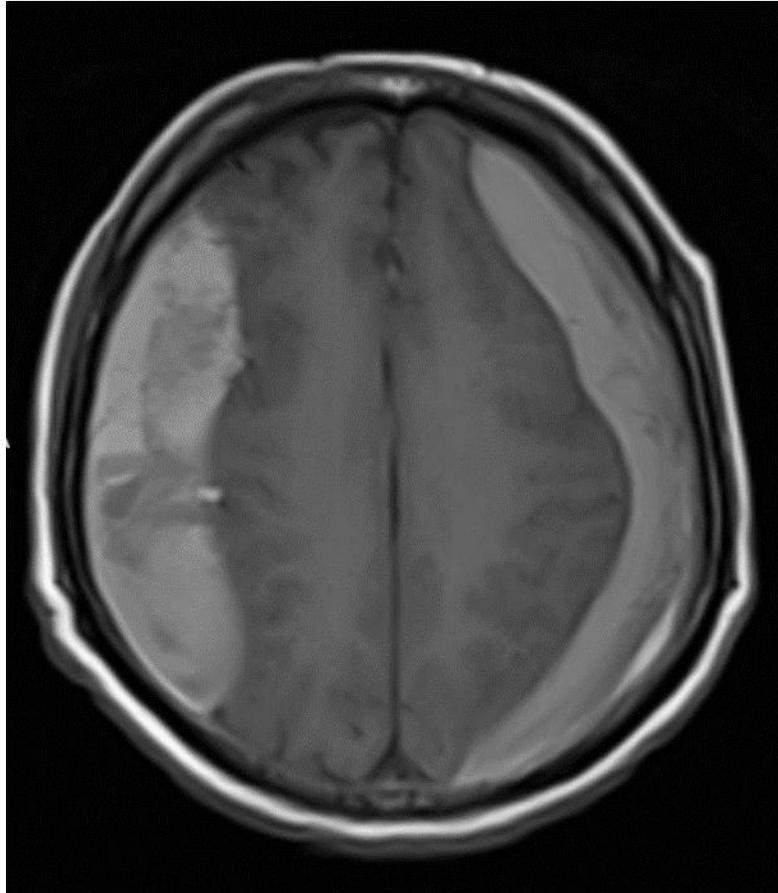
MRI Brain showing bilateral chronic subdural hematoma
